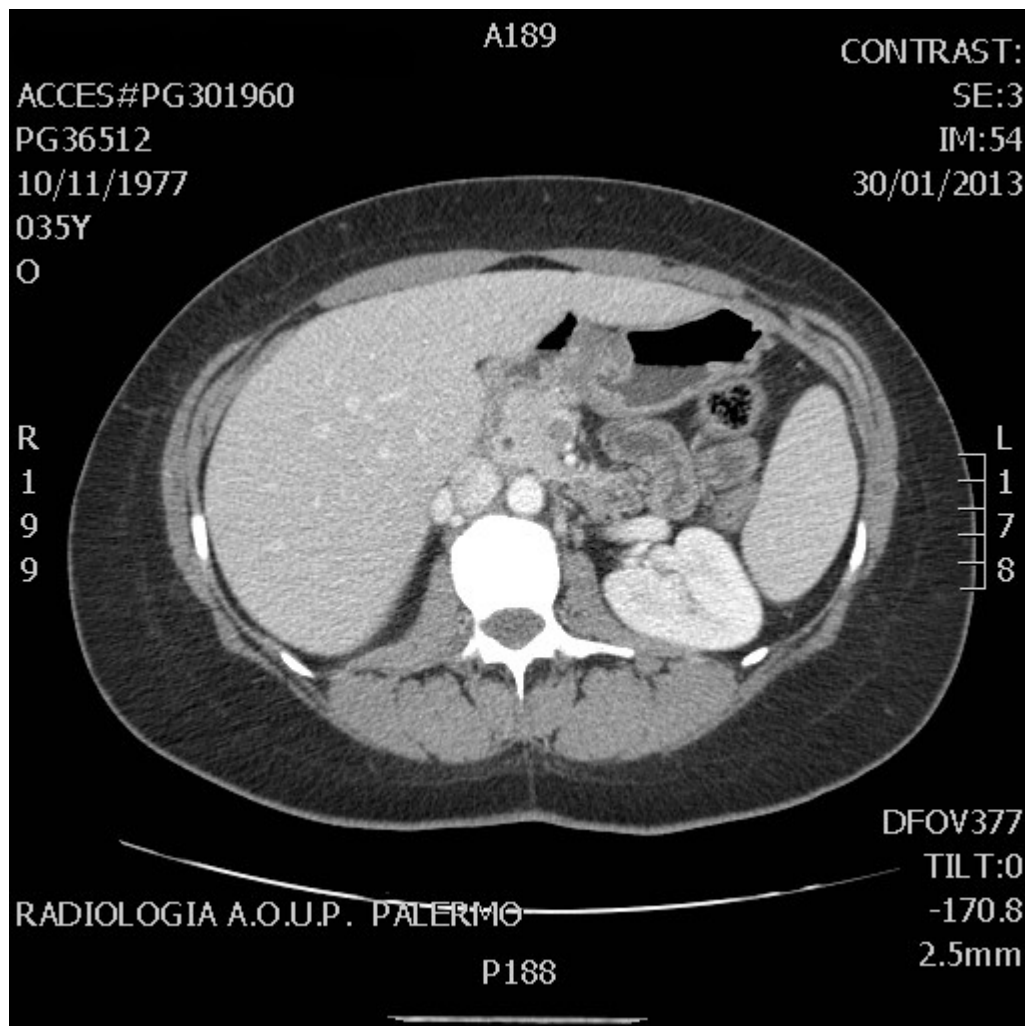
Contrast-enhanced CT scan. Complete thrombosis of the superior mesenteric vein and its distal branches, associated with hyperdense congestive perivascular fat deposition.
